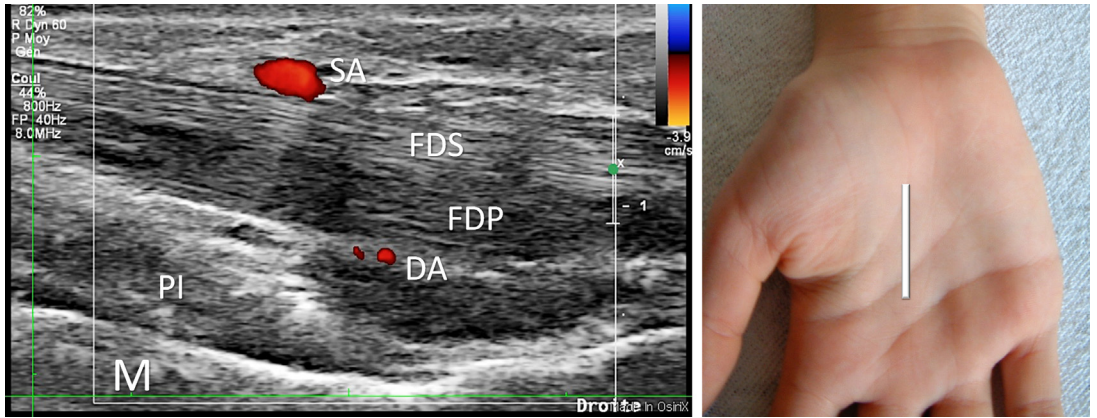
In the palm, the SA lies superficial to the flexor tendons and is well demonstrated with color Doppler US; the DA is not always clearly identified at the level of the metacarpals and the palmar interosseous muscles. PI, palmar interosseous; SA, superficial arterial arch.
